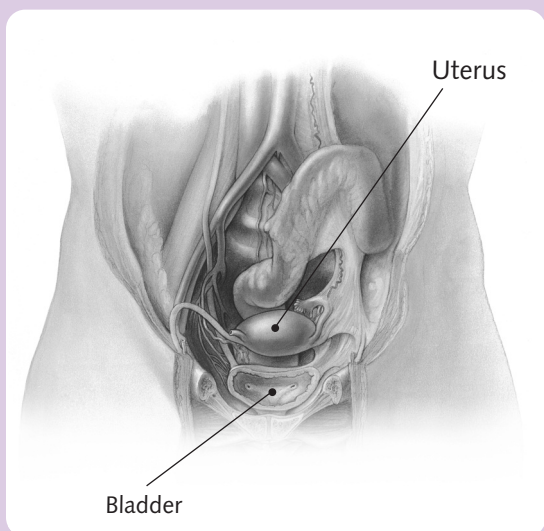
Female pelvic anatomy, anterior view. MR imaging protocols generally cover the pelvic contents from sidewall to sidewall, using multiplanar T2 and T1 imaging.
